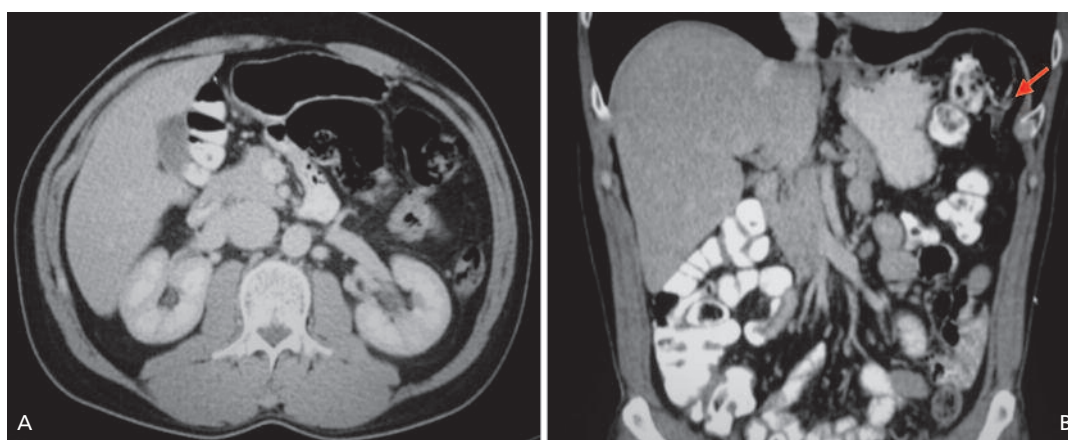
A-B. Axial and coronal views of abdominal CT scan show small air packets in the colon.
